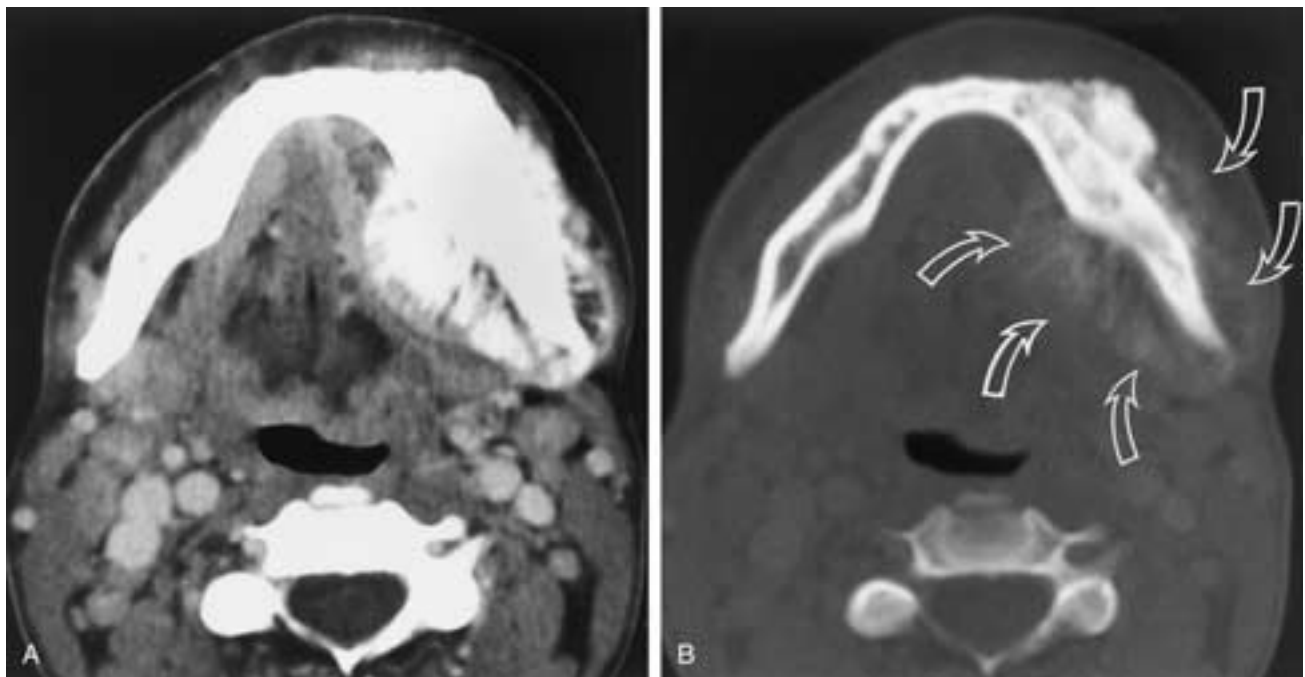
Mandibular osteogenic sarcomas in two different patients. Contrast-enhanced axial CT scans in soft-tissue (A) and bone (B) windows reveal masses arising from the mandible and involving both the buccal and lingual surfaces. The characteristic spiculated periosteal reaction is noted in both tumors, more prominently on the bone window image (*arrows* in B).
